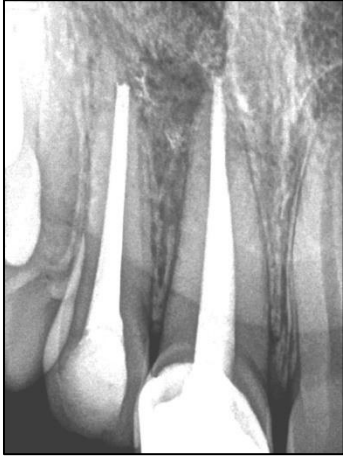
12 months follow up radiograph.
